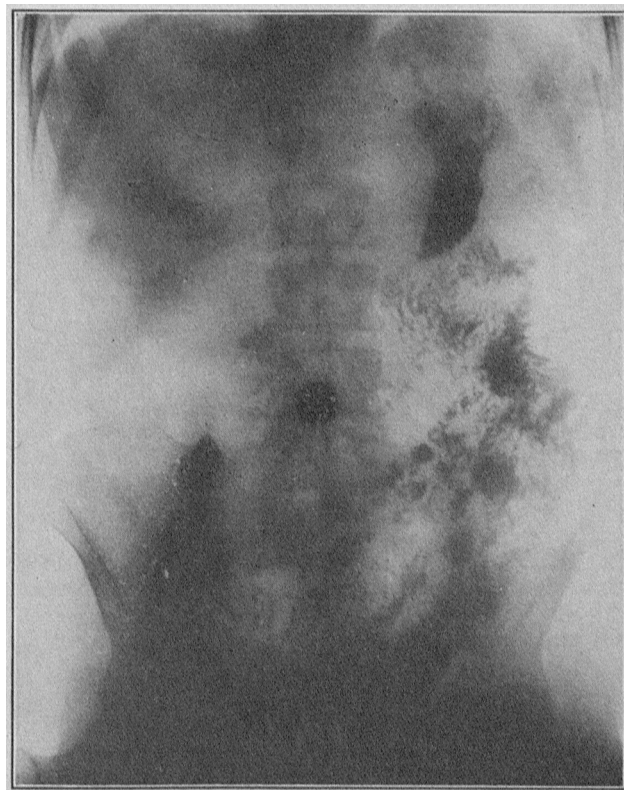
View of gastro-intestinal tract, taken immediately after the ingestion of 500 c.c. of bismuth and fermented milk. Note the extensive dissemination in the small intestine. This and the following radiograph were taken by Dr. R. D. Carman.
